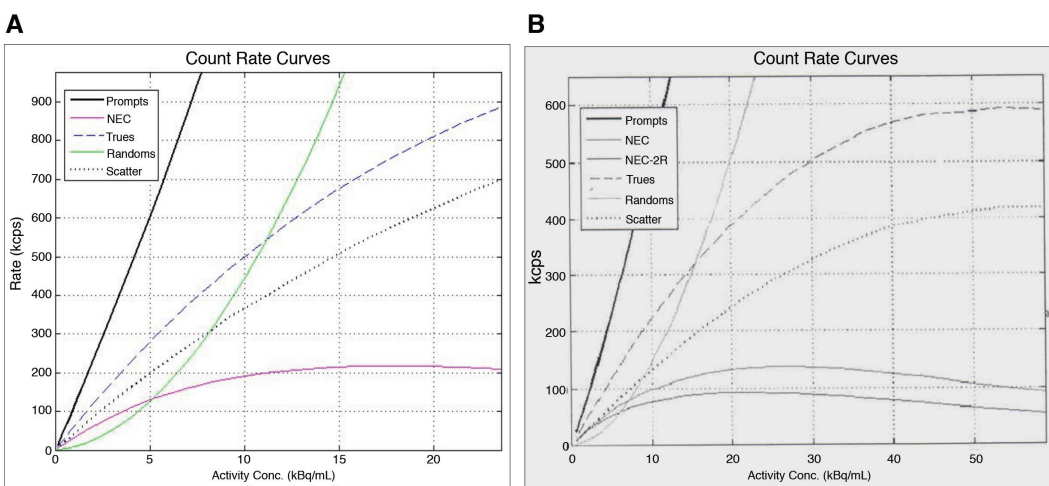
Positron emission tomography/magnetic resonance (A), positron emission tomography/computed tomography (B) measured noise equivalent count rate values
